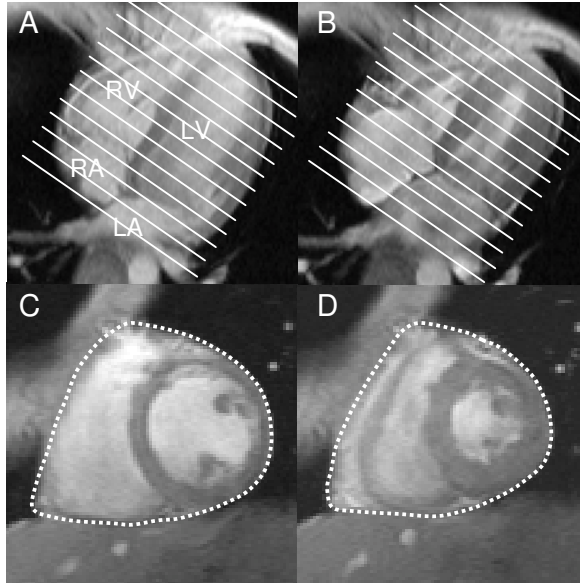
Measurement of cardiac volumes by MRI. The top panels show long-axis views of the heart in end diastole (A) and end systole (B). The heart is imaged from apex to base in the short axis view (bottom panels) as indicated by white lines in A and B. The dotted lines in the bottom panels indicate the pericardial borders of the heart in end diastole (C) and end systole (D). The volumes of all slices are added to obtain the entire volume of the heart.
